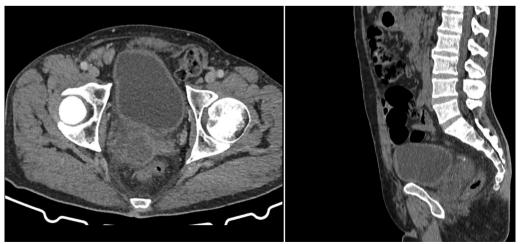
CT scan of the pelvis showing enlarged heterogeneous prostate with two collections associated to right seminal vesicle collection
